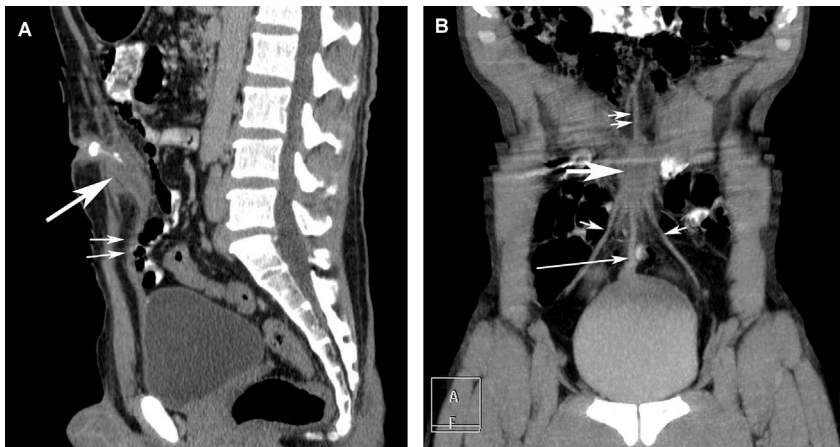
Midsagittal intravenous contrast enhanced CT scan image with umbilical instillation of contrast (A) and Excretory phase coronal CT image (B) showing fusiform abscess (large white arrow in A and B) extending from umbilicus superiorly to thickened median umbilical ligament (small white arrows in A and long white arrow in B) inferiorly. Medial umbilical ligaments (small white arrows in B) and ligamentum teres (double arrows in B) are seen.
